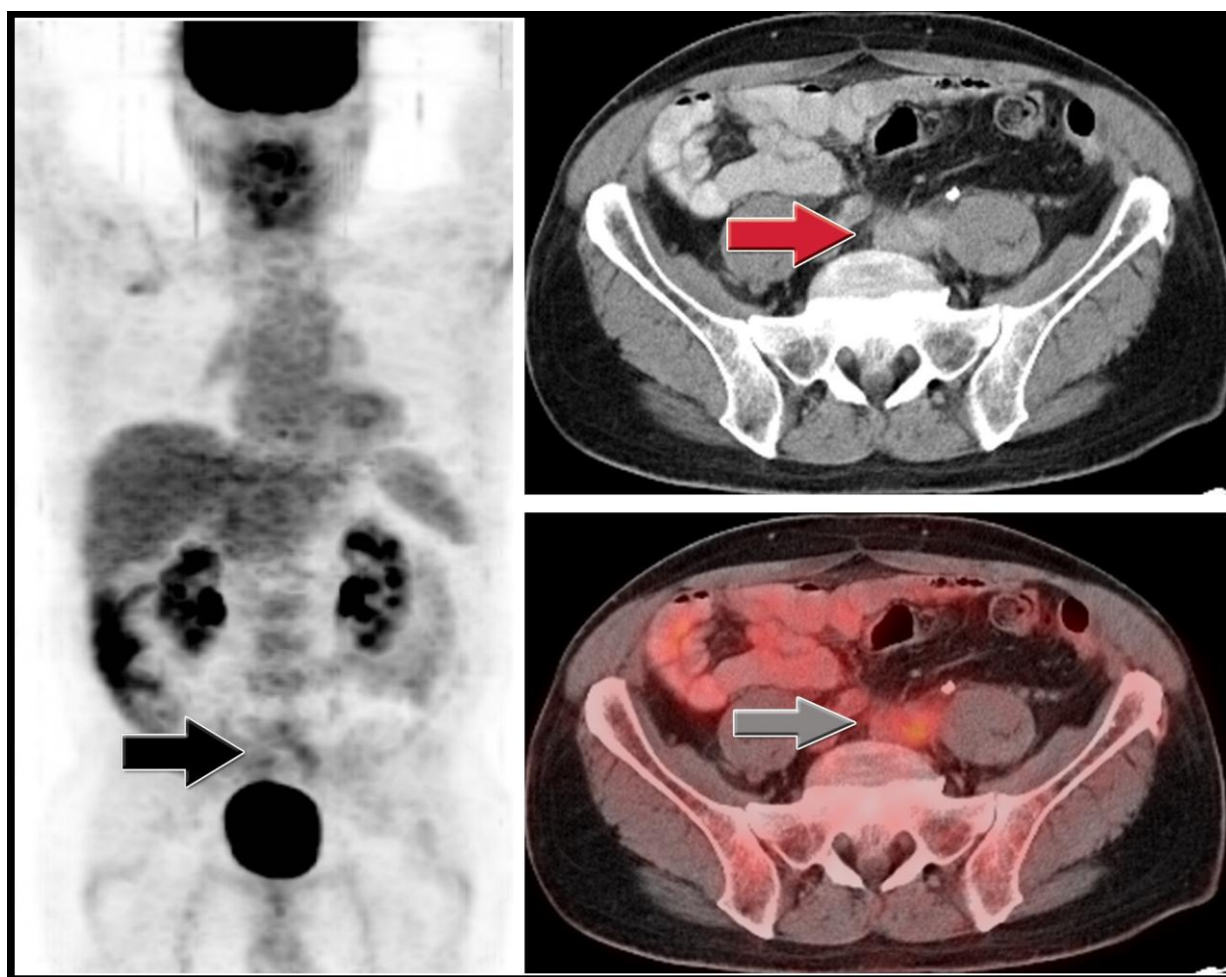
(left) PET coronal, (upper right) CT axial, and (lower right) PET/CT axial views of a 58 year-old man with (unknown) retroperitoneal fibrosis, undergoing initial PET/CT to evaluate for potential lymphoma. Diffuse moderate FDG activity corresponding to CT soft tissue abnormality is seen as an infiltrative soft tissue mass surrounding left common iliac artery and vein causing minimal compression of the vessels. (Performed 60 minutes after injection of FDG tracer, dose of 17.53 mCi, with 5 mm slice thickness, CT-based attenuation correction algorithm using two iterations and 8 subsets, 120 kVp, 112 mAs.)
